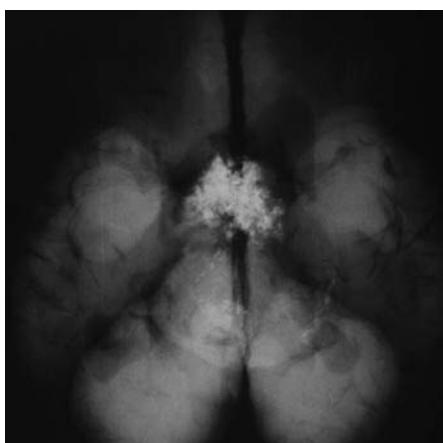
Large adamantinomatous craniopharyngioma extending into the third ventricle. Note the dorsal portion resembling 'machine oil'. Postmortem X-ray showed extensive calcification.
